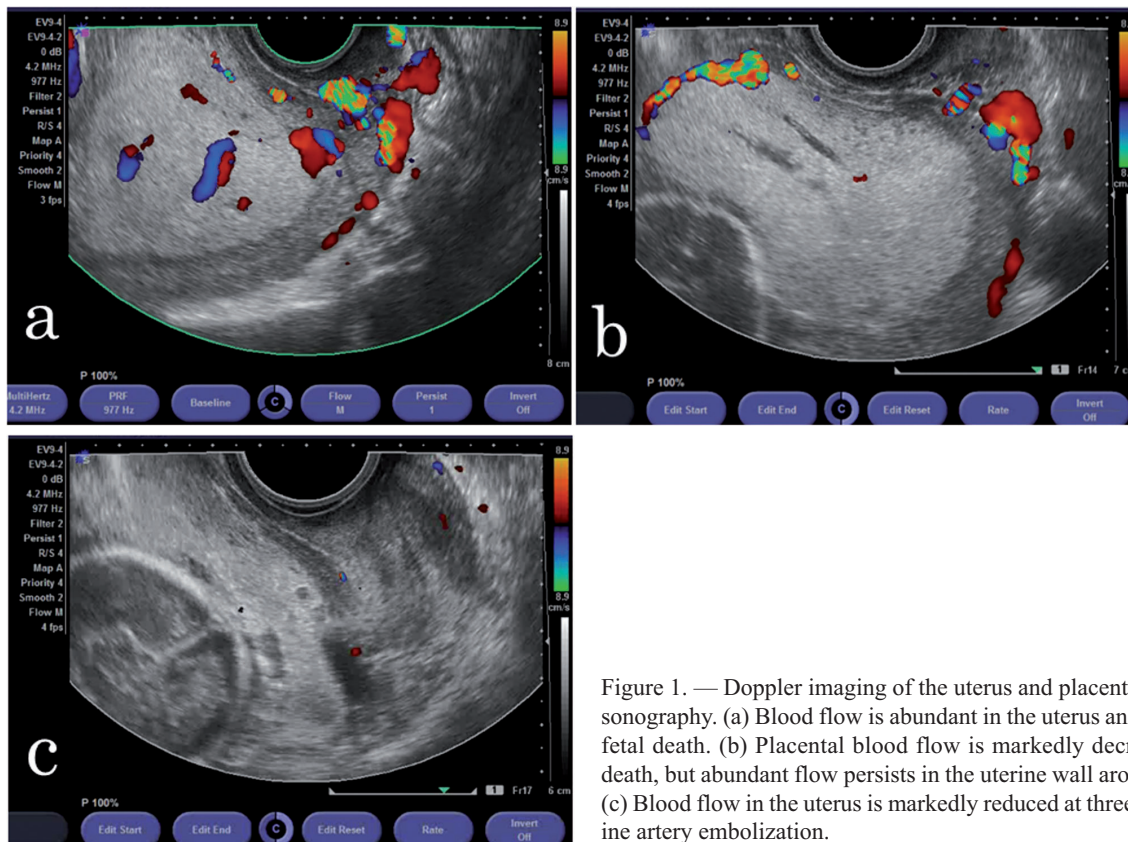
Doppler imaging of the uterus and placenta by transvaginal sonography. (a) Blood flow is abundant in the uterus and placenta before fetal death. (b) Placental blood flow is markedly decreased after fetal death, but abundant flow persists in the uterine wall around the placenta. (c) Blood flow in the uterus is markedly reduced at three hours after uterine artery embolization.
